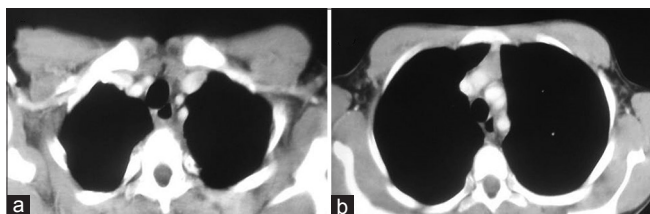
(a and b) Computed tomography (CT) of the chest showing complete resolution of the lesion after treatment
